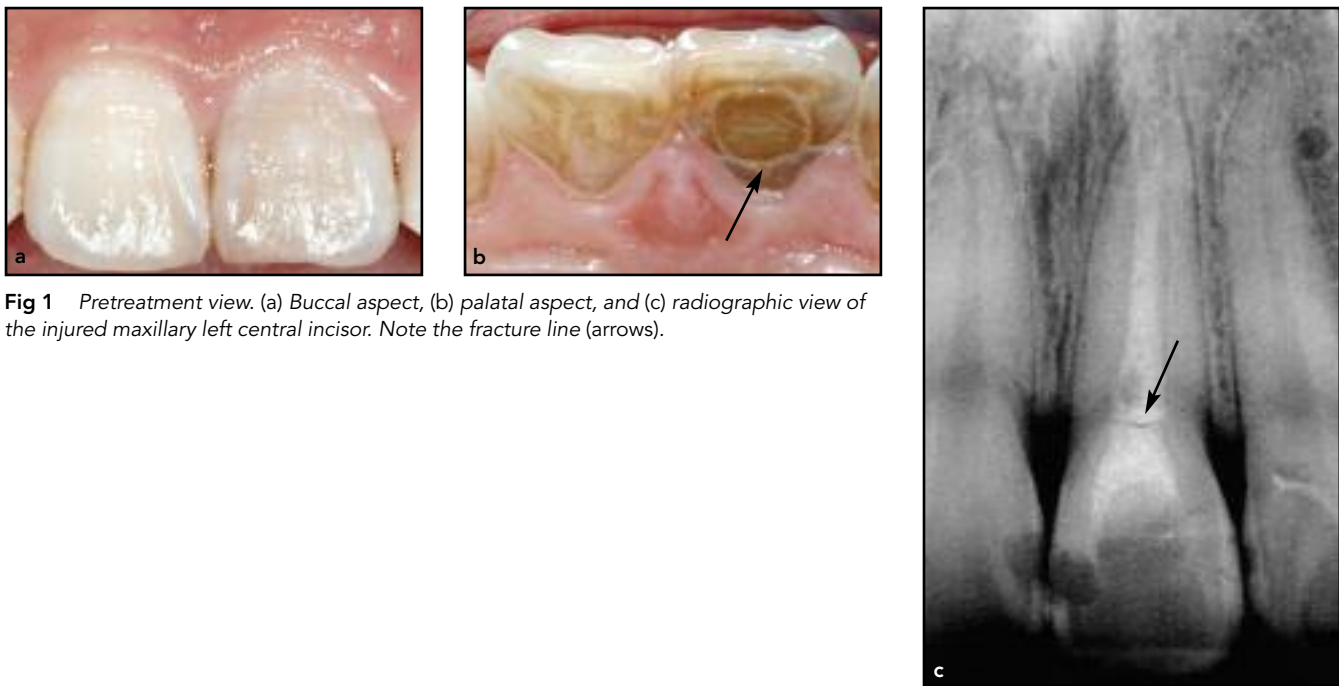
Pretreatment view. (a) Buccal aspect, (b) palatal aspect, and (c) radiographic view of the injured maxillary left central incisor. Note the fracture line (arrows).
